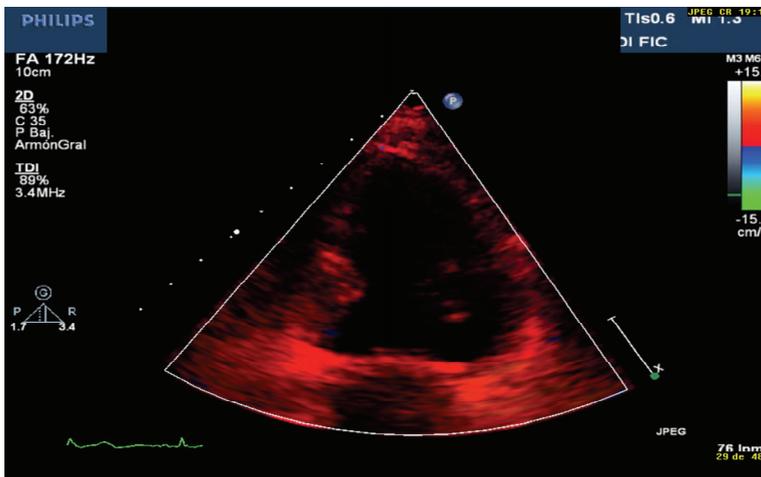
Myocardial motion in DT shown as color-coded speeds of ultrasound scan lines within a 2D sector
